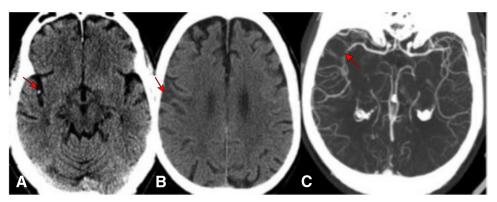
Demonstration of distal dense middle cerebral artery sign on noncontrast computed tomography (NCCT) with contrastenhanced CT confirmation. (A) Focal hyperdensity of the right middle cerebral artery M2 segment within the cistern of the lateral cerebral fossa (arrow). (B) Hypodensity of the right inferior frontal gyrus representing recent infarction (arrow). (C) A maximum intensity projection image from the subsequent contrast-enhanced CT angiogram demonstrates a filling defect (arrow) within a right sylvian M2 branch, corresponding to the clot on NCCT and in the arterial territory of the infarct.
